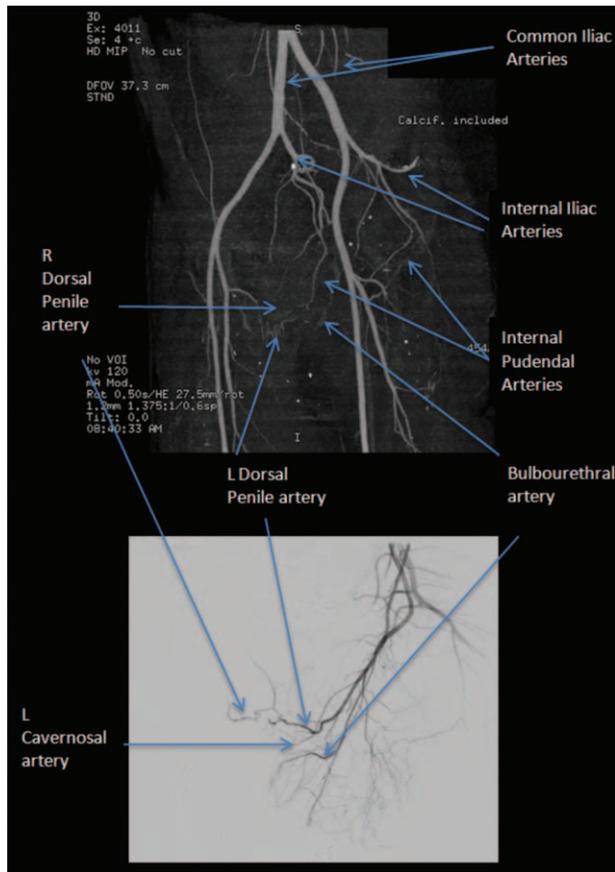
CT angiography and conventional angiography.
